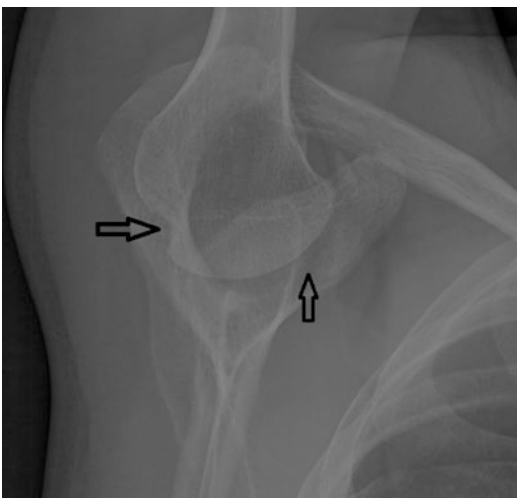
Hill–Sachs lesion in Stryker view, X-ray examination
